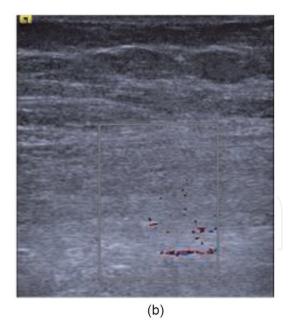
Ultrasound picture of normal muscle tissue (a) and muscles with hyperechogenic ultrasonic signal due to DMC (b).
